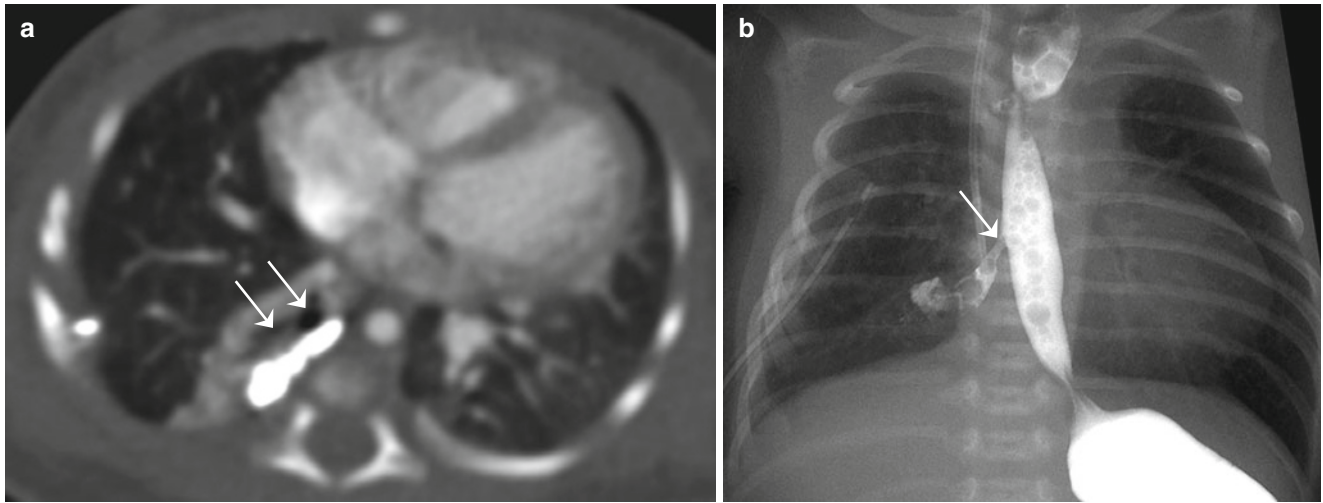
(a, b) Esophageal bronchus. Axial CT image shows the collapsed right lower lobe with air bronchograms (*arrows*) that do not connect to the tracheobronchial tree (a). Residual thin barium is noted
